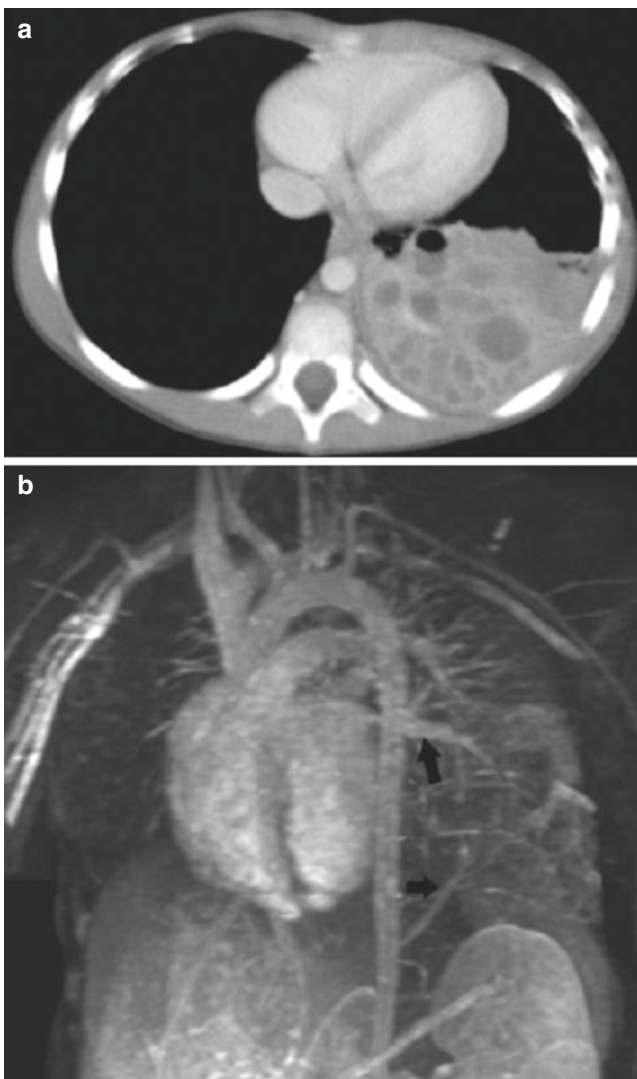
Intralobar pulmonary sequestration in a 12-year-old boy who presented with pneumonia. (a) Axial enhanced CT image shows a complex left lower lobe mass with areas of fluid and enhancing septations by CT. (b) MRA shows two large feeding vessels (arrows) arising from the aorta. Pathology after surgical resection proved intralobar pulmonary sequestration
